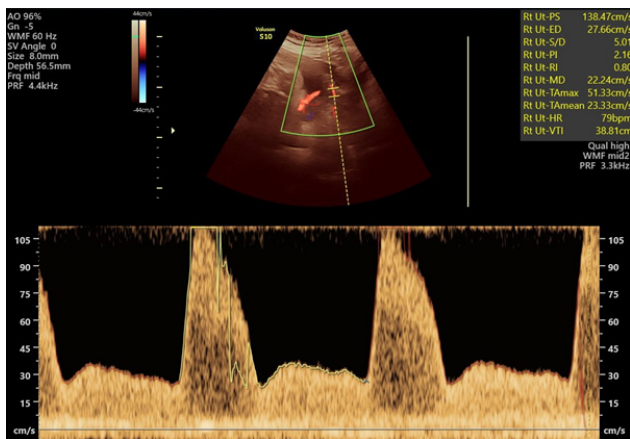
Uterine artery Doppler with high PI and persistent uterine notch UTA-PI=2.16, UTA-RI=0.80
